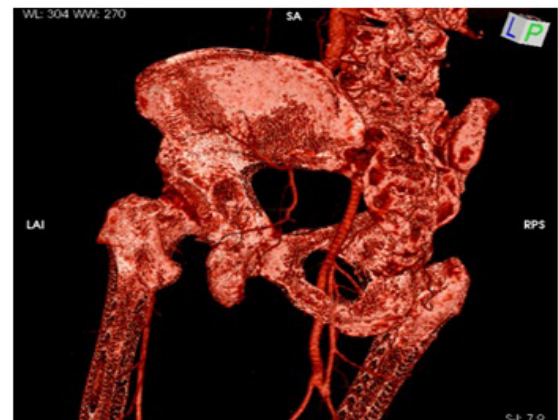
3D-Angio-CT reconstruction (postero-lateral view) perfectly showing the graft crossing the obturator foramen.
